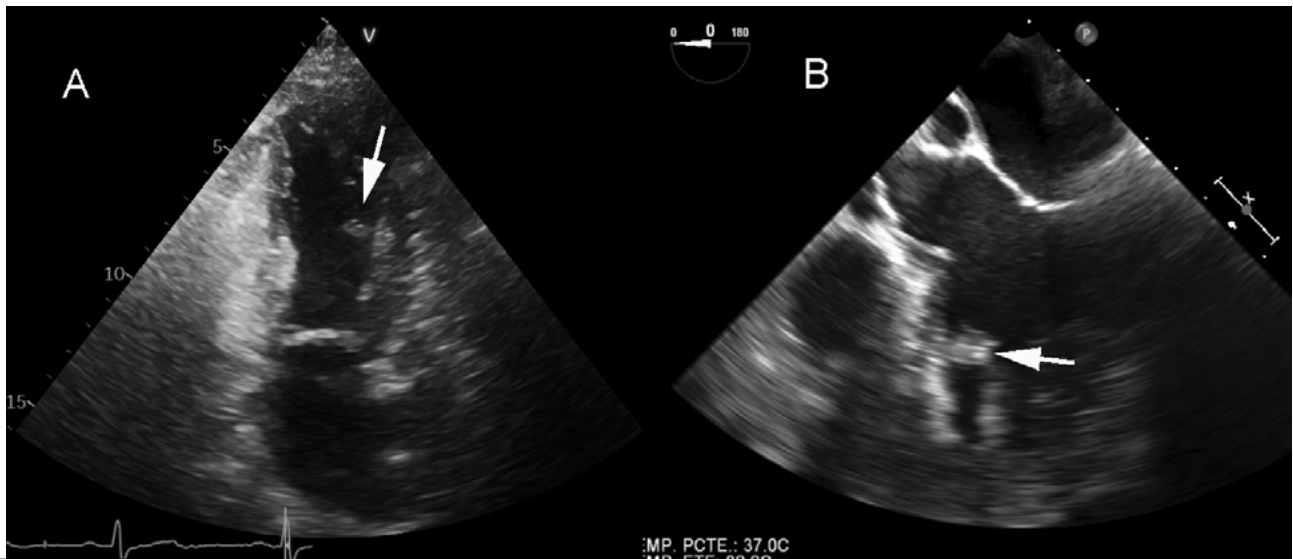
Transthoracic and transesophageal echocardiography. A. Apical two-chamber view on transthoracic echocardiogram showing a 1x1 cm mass (arrow) arising from the anteroseptal wall of the left ventricle. B. The same mass is seen in apical five-chamber view on transesophageal echocardiogram (arrow).*
